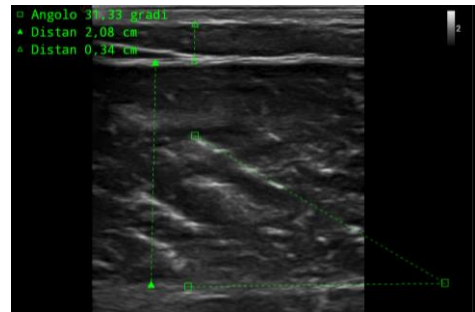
ULTRASOUND MEASURES
